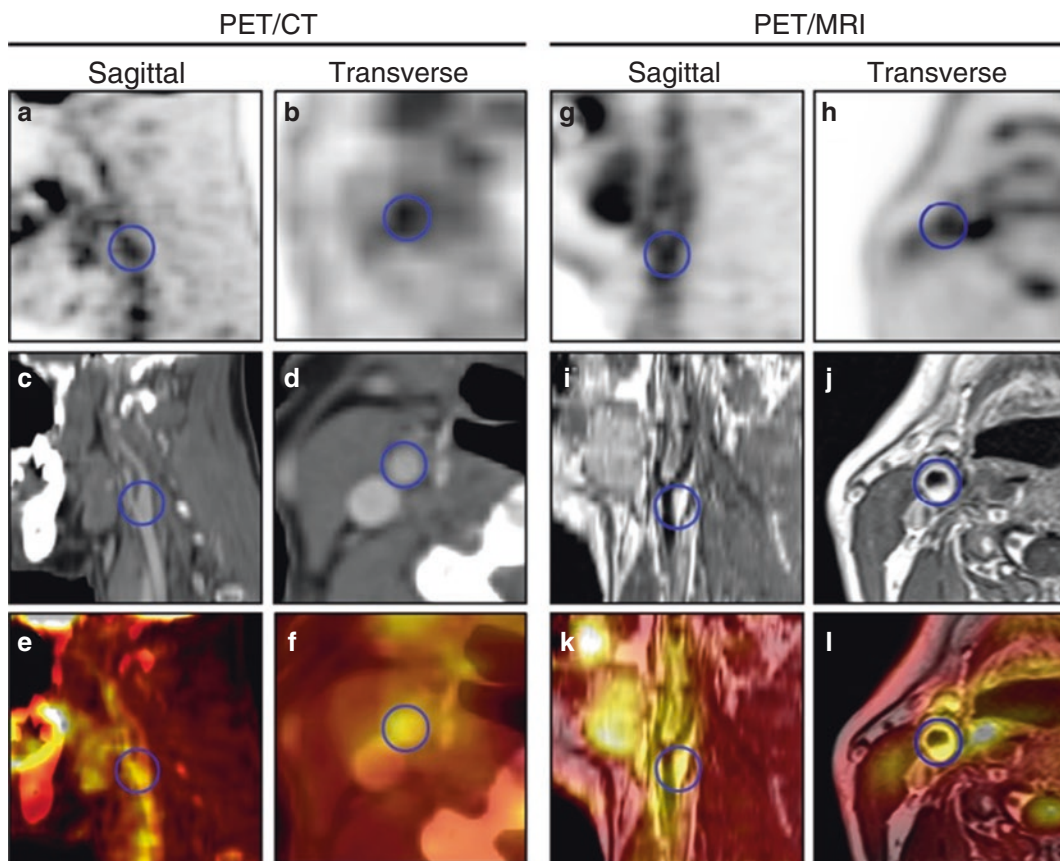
Integrated PET/CT and MR images of the right carotid artery in a patient with head and neck cancer. A 52-year-old male patient whose right carotid plaque
